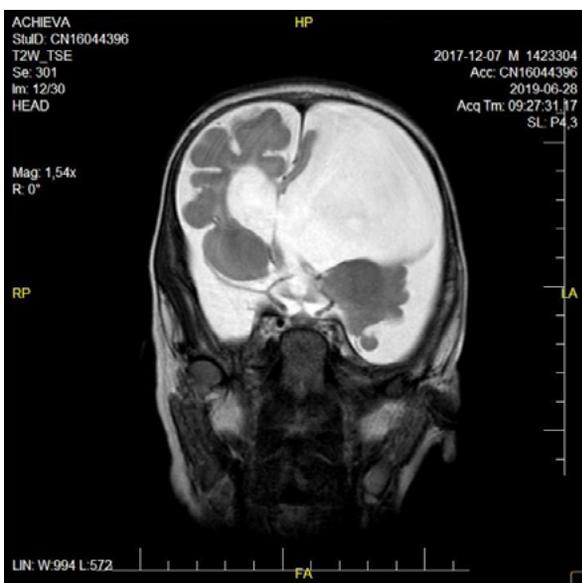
Magnetic resonance imaging (MRI) scan of the brain (case 3)
